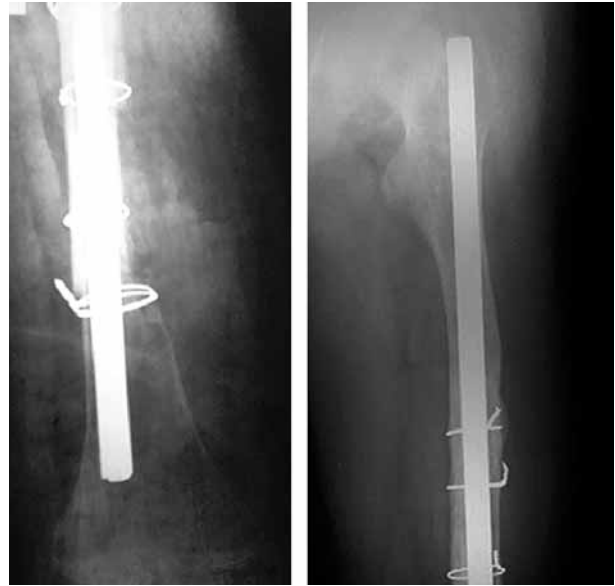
Anteroposterior radiograph 10 weeks after conventional nailing and additional cerclage wiring of the intra-operative longitudinal fracture.
